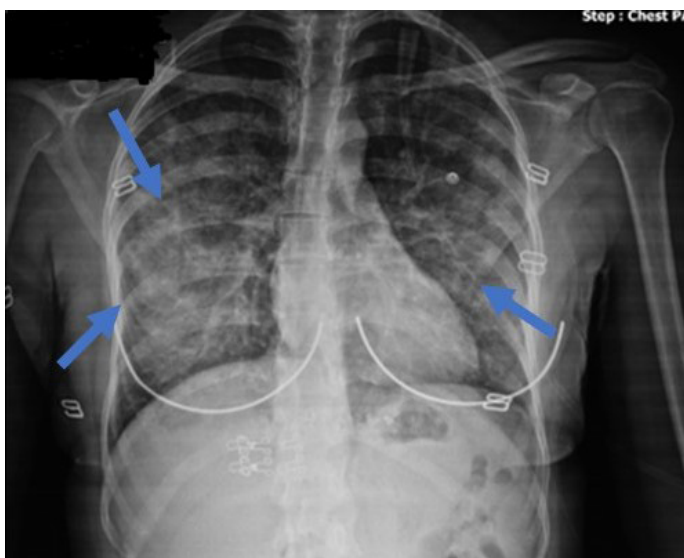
Chest X-ray: Diffuse reticulonodular pattern
